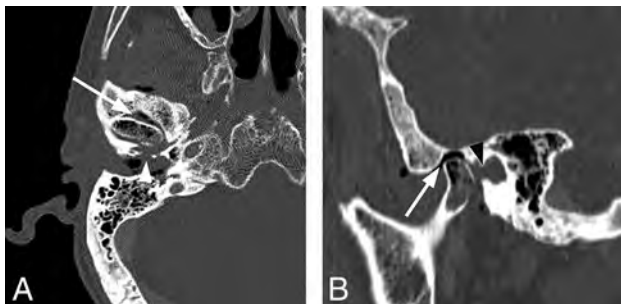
Necrotizing external otitis complicated by septic temporomandibular joint arthritis. An 88-year-old man with several months of right ear pain and drainage presented with progressive symptoms and right temporomandibular joint pain and trismus. In the prior weeks, he had been treated for NEO with oral and IV antibiotics at an outside facility. After initial evaluation, debridement and temporomandibular joint replacement were planned, but the patient was lost to follow-up. A, Axial contrast-enhanced CT with bone windows demonstrates abnormal opacification of the right EAC and inferior middle air cavity. There is erosion of the floor of the EAC, potentially involving the foramen of Huschke (arrowhead), and communication with the right temporomandibular joint (arrow) as well as within the mandibular condyle itself. B, Sagittal reformatted CT scan again demonstrates abnormal air density within the right temporomandibular joint and mandibular condyle (arrow). Note a defect in the anterior inferior margin of the EAC (black arrowhead).
